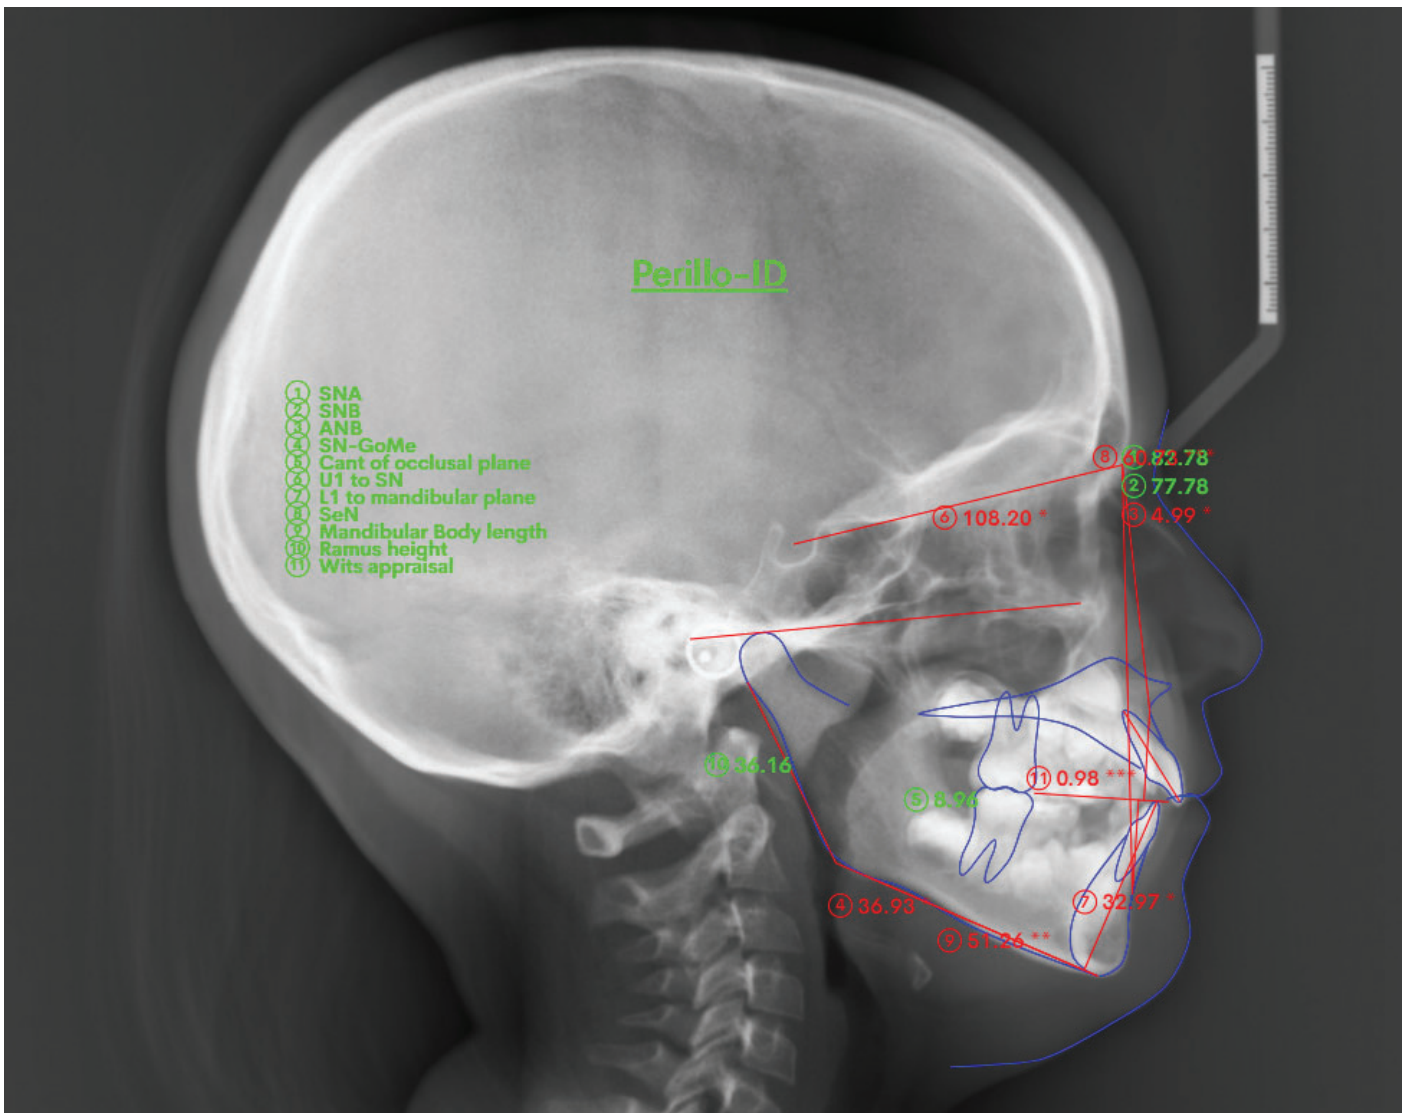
X-ray image of skull lateral view. Contoured bony/soft tissue structures and reference lines forming Perillo-ID cephalometric analysis. Cephalometric measurements by Perillo-ID cephalometric analysis.
